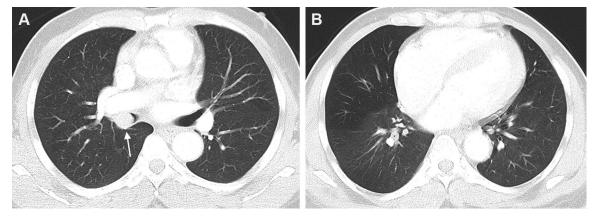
A-B, Axial CT images on lung windows in a 61-y-old man with cough secondary to a 2-cm carcinoid tumor in the bronchus intermedius (A, arrow) with associated air trapping in the right middle lobe (B).
